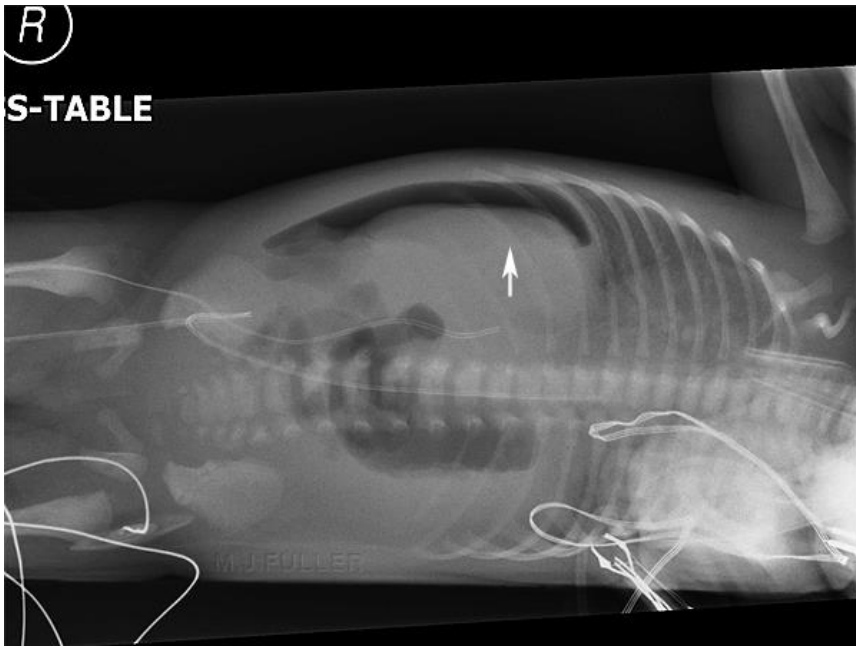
(A,B). A: Abdominal x-ray film obtained in left lateral decubitus with horizontal x-ray beams, left lateral decubitus with horizontal x-ray beams, where pneumoperitoneum is demonstrated between the liver and the right abdominal wall. B: Scheme demonstrating the NN positioning to be adopted for study in left lateral decubitus with horizontal beam to demonstrate pneumoperitoneum (reference 16).
